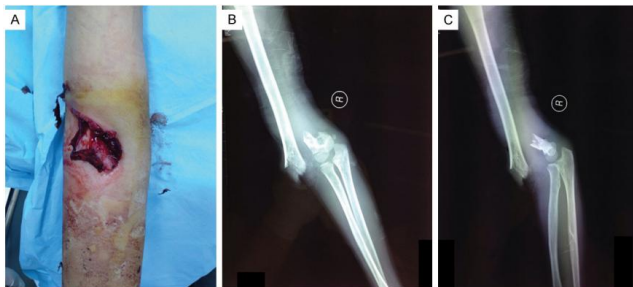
A) Preoperative view of the fracture. The right elbow was markedly swollen. A 4-cm wound is seen on the flexural aspect of the elbow, indicating severe contamination of the fracture site. B) and C) Preoperative radiography shows Gartland type IIIb supracondylar humerus fracture with severe displacement
